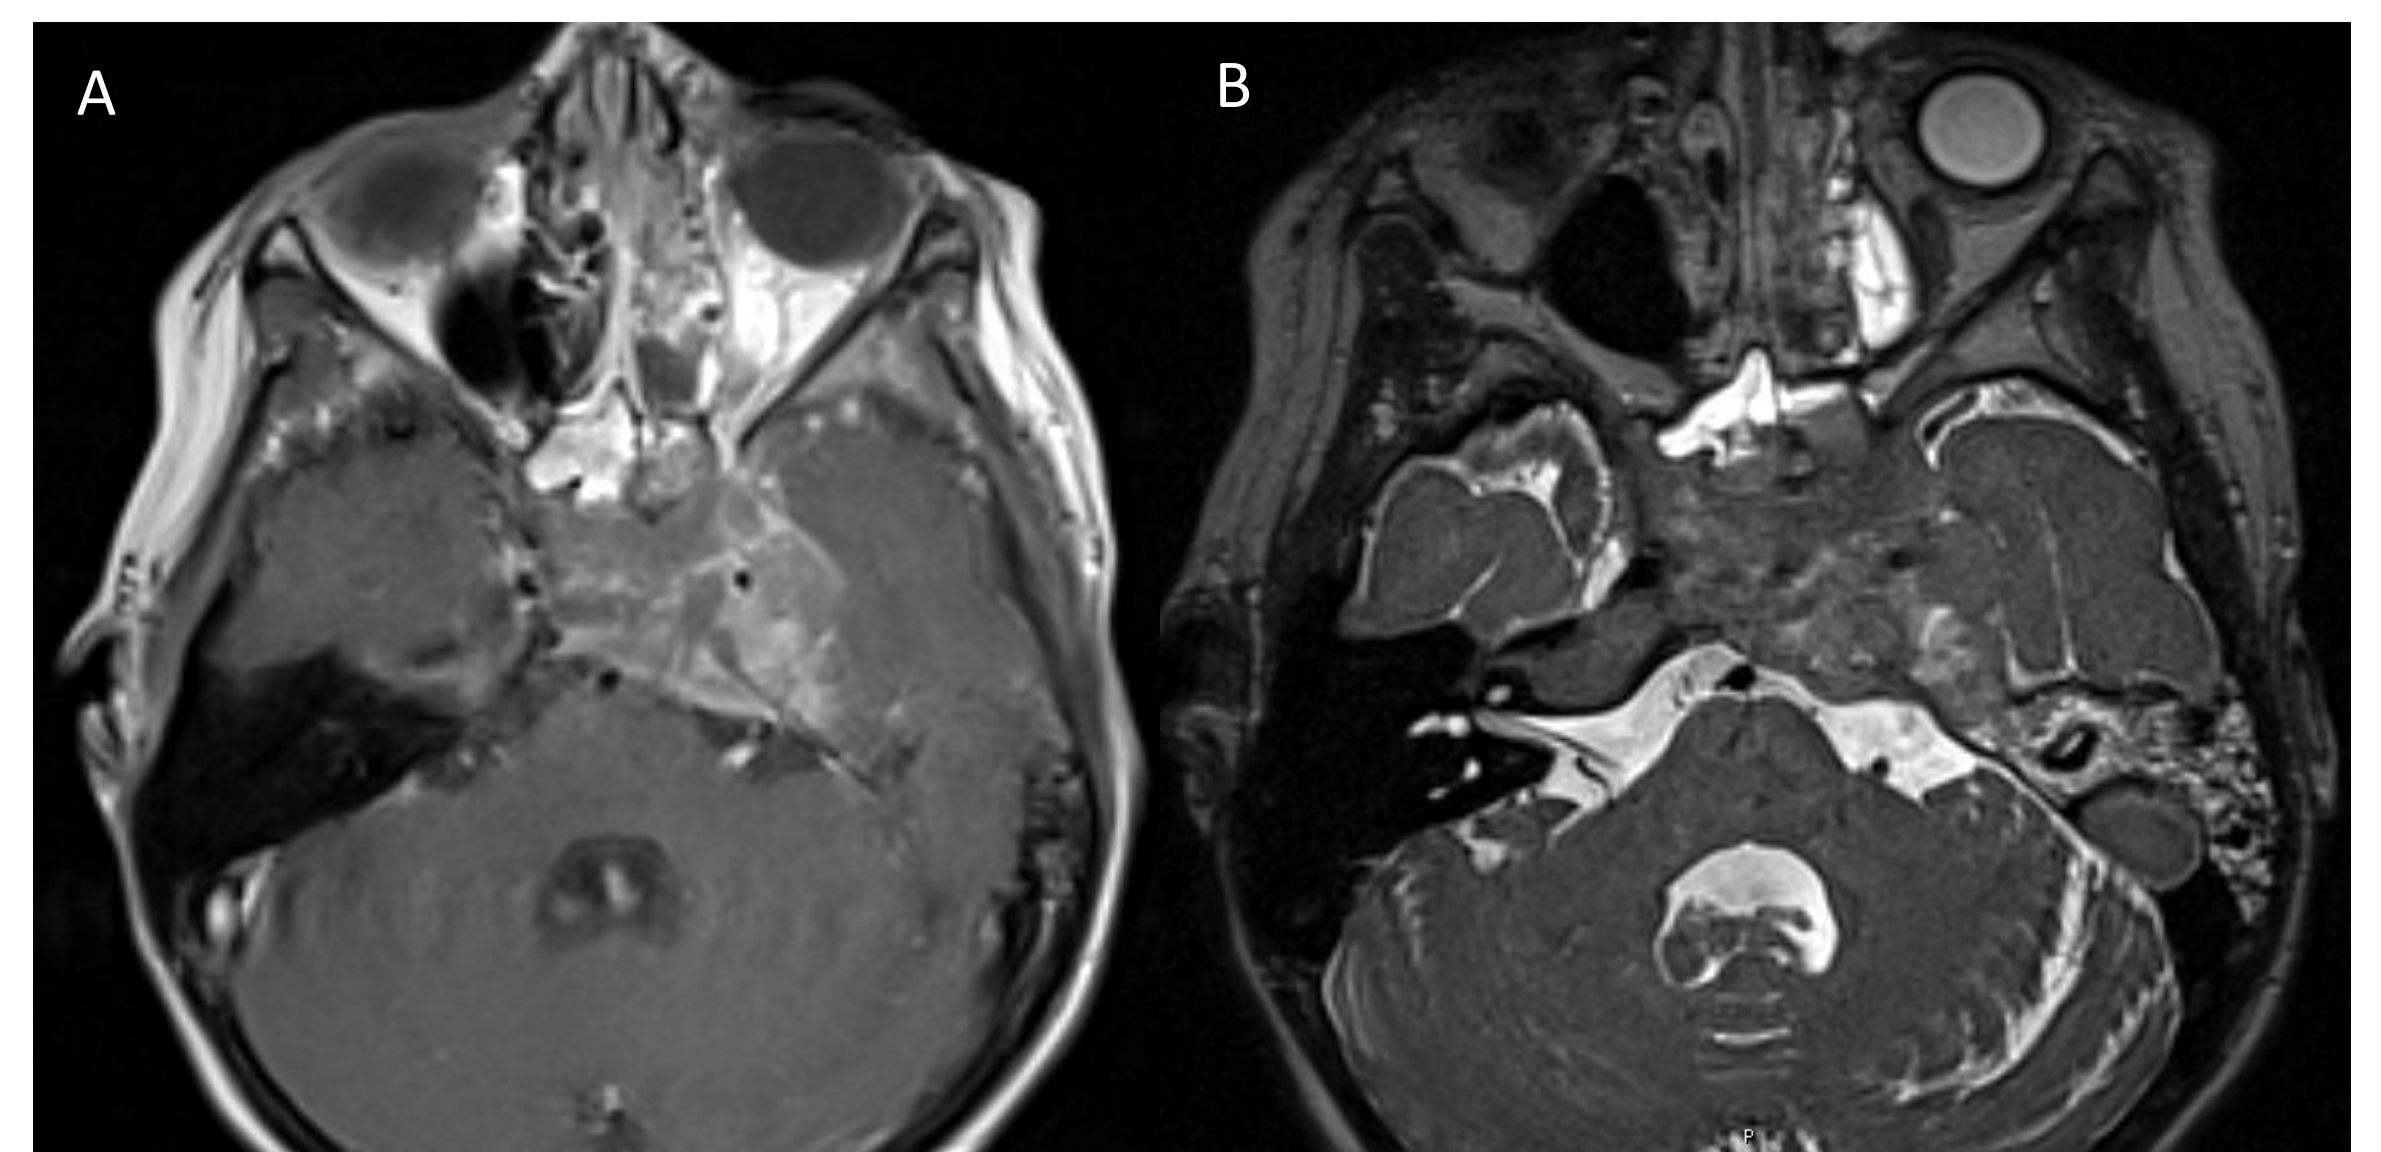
Repeat MRI at 2.5 weeks A) T1 with contrast and B) T2 demonstrated rapid growth of the petrous apex lesion now extending into nasopharynx and sphenoid sinus.
